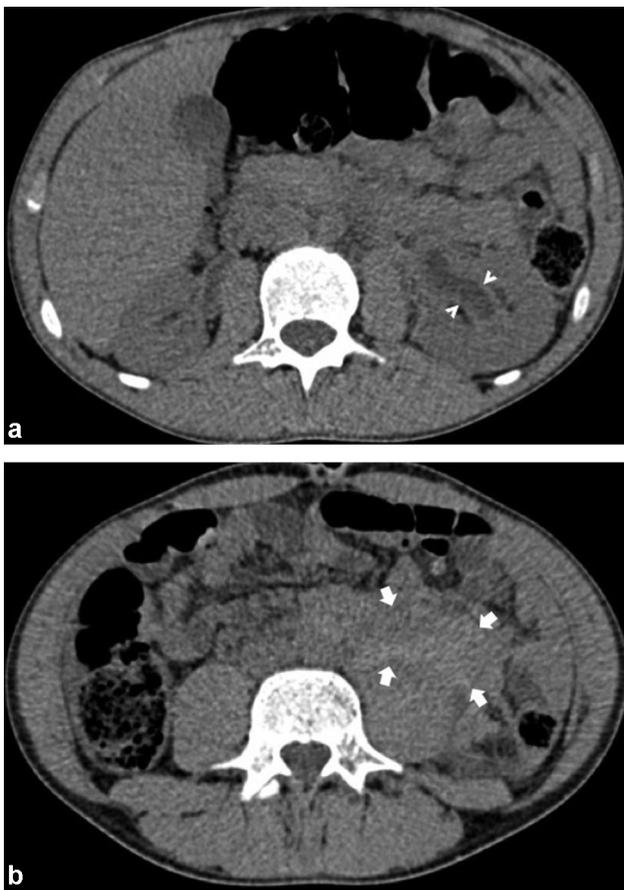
17-year-old boy with severe hemophilia A presenting with acute left flank pain and negative hematuria. Unenhanced abdominal CT images in the transverse plane (A and B) show a left ureteral hematoma as a spontaneously hyperattenuating thickening of the left renal pelvis (arrowheads on A) and a left retroperitoneal hematoma (arrows on B) extending in front of the psoas muscle. Persistent thickening of the contralateral renal pelvis due to a right ureteral hematoma occurring six months earlier is also present. Trauma with baton twirling was suspected in both episodes.
